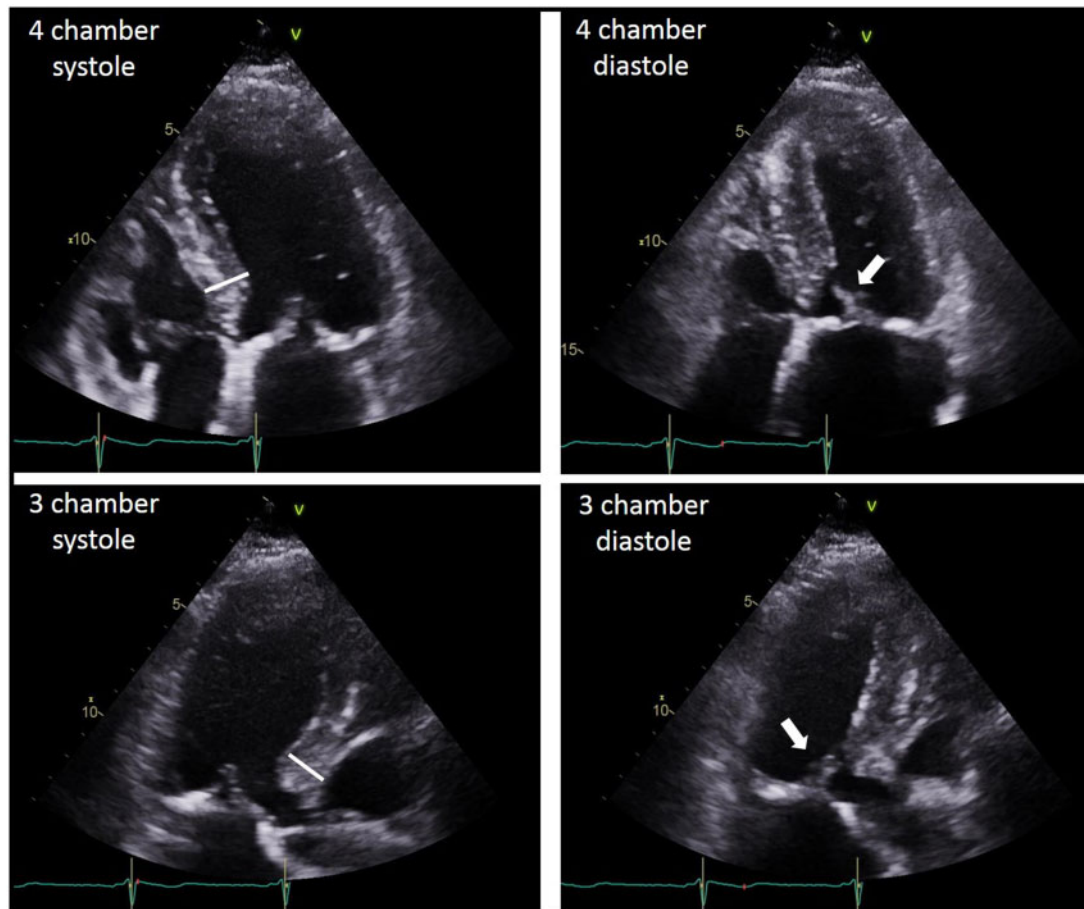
Echocardiography. Four-chamber and three-chamber views show moderate basal septal hypertrophy (white line) and mitral valve systolic anterior motion into the left ventricular outflow tract (white arrow).
